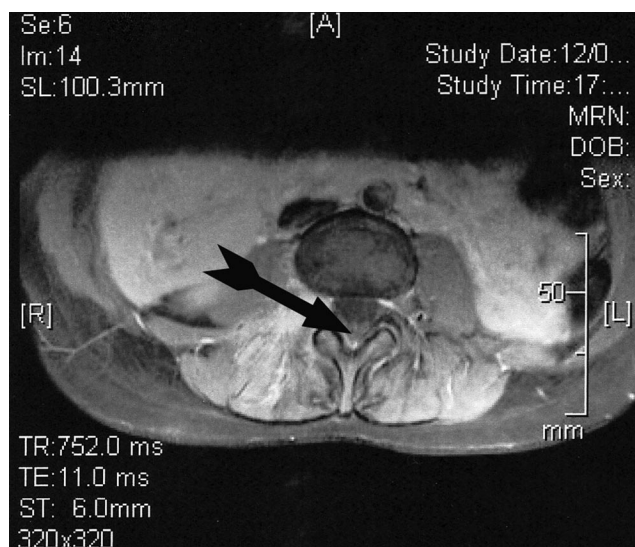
Transverse view spinal magnetic resonance image. Arrow points to a 1.3-cm rounded epidural lesion at the right neural foramen of L3-L4 with enhancement of the paraspinal muscles posteriorly and the right pedicle of L3-L4.
